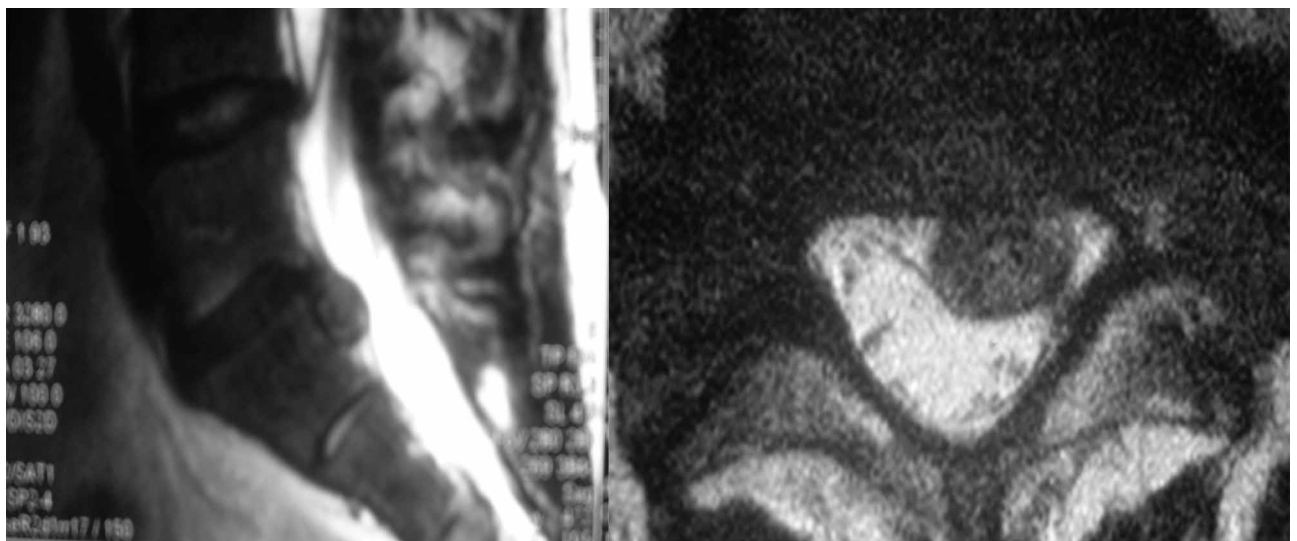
MRI shows disc extrusion.
